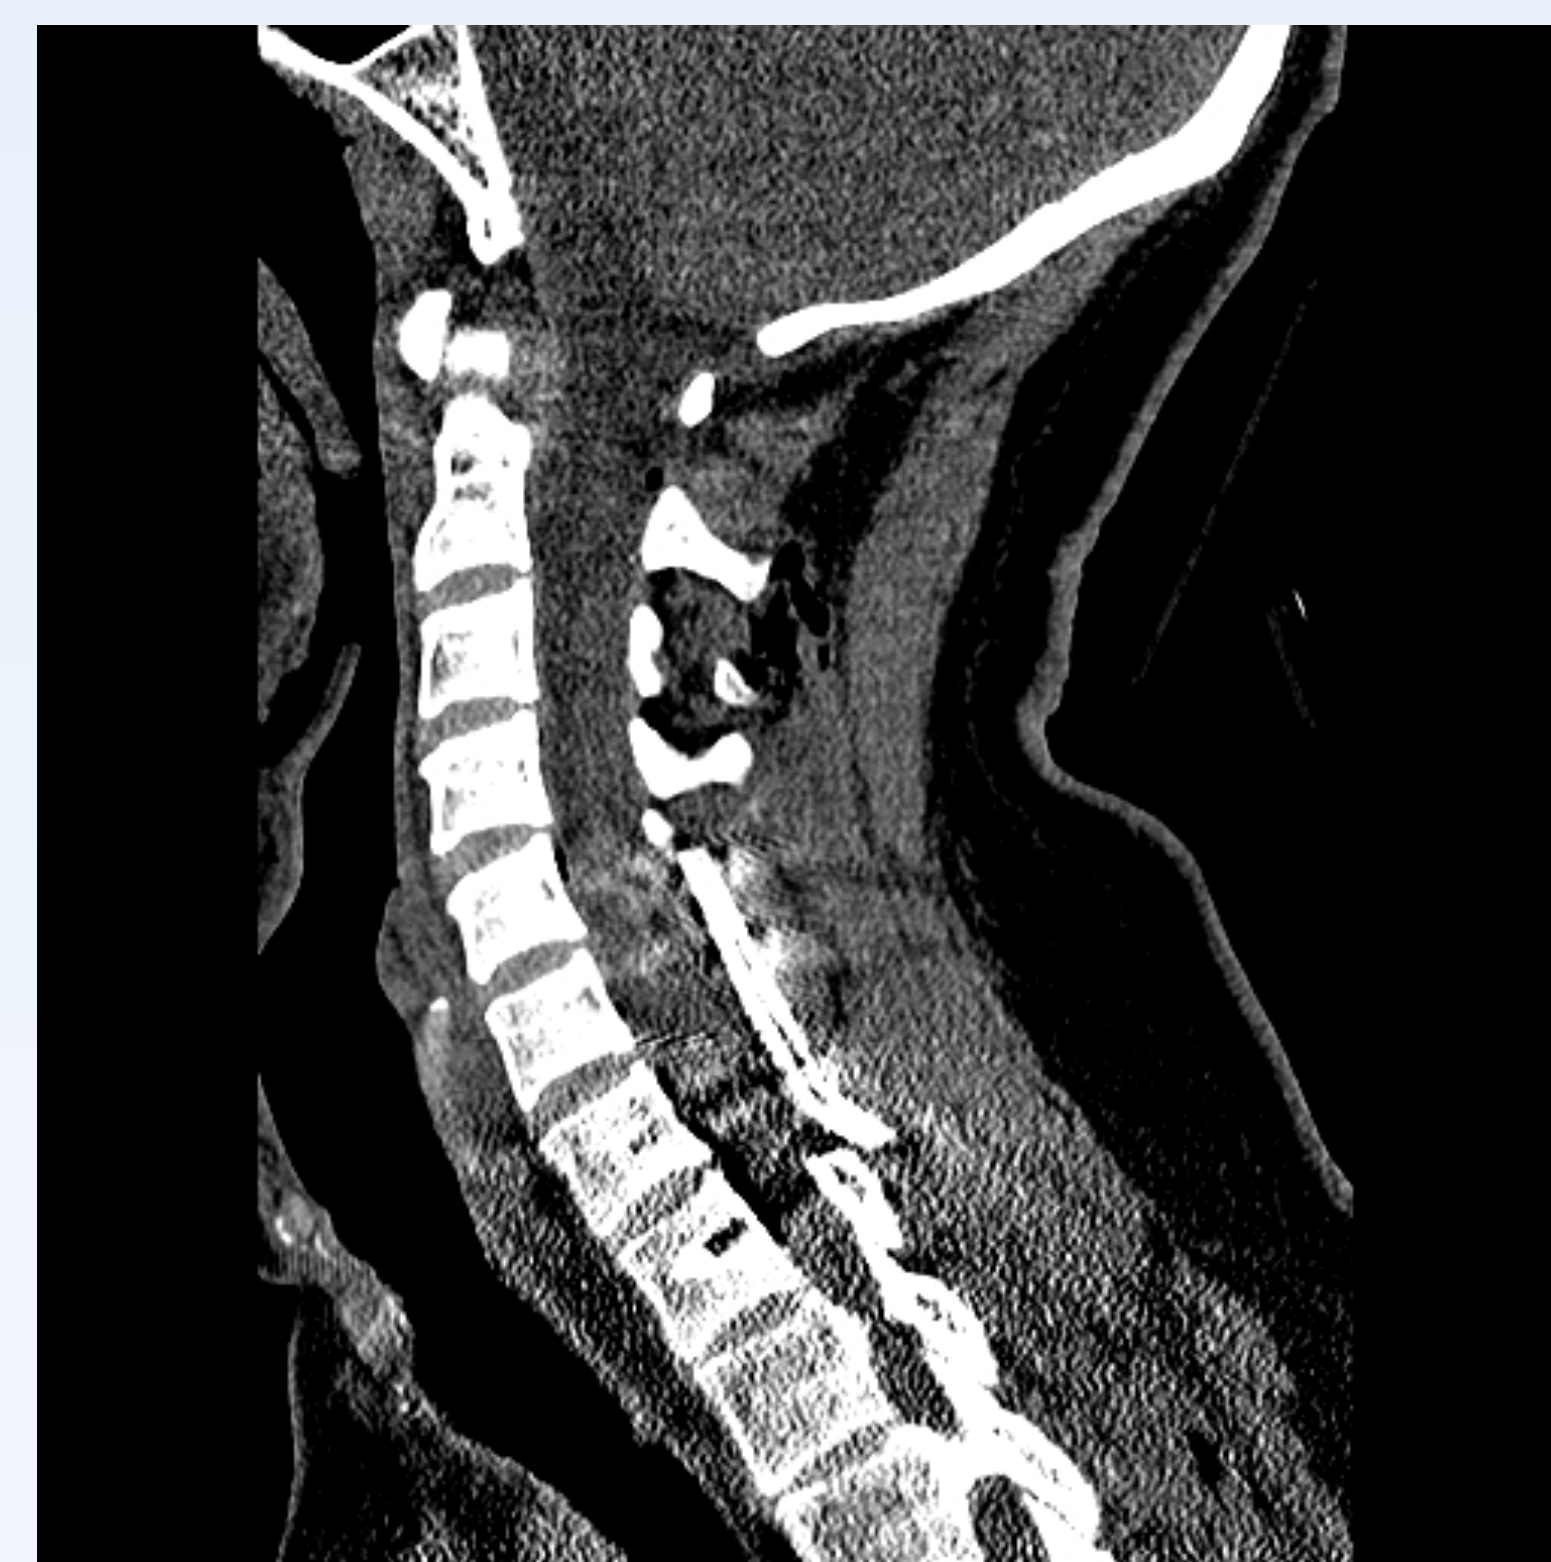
Post-Op CT C-spine
